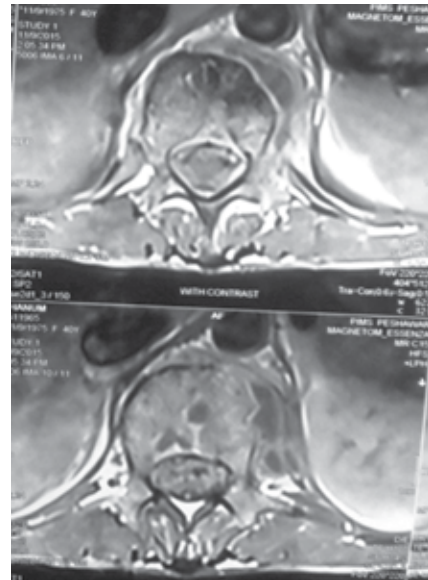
Post contrast axial MRI image of lumbar spine shows enhancement of the involved vertebrae along with minimal pre and left side para vertebral collection.
